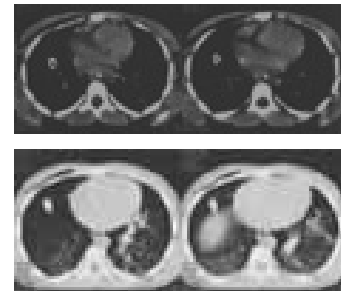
(a-d). Right subcutaneous emphysema (at all scans) and left pneumothorax (at right upper scans) in thoracic CT after settling bilateral thoracic tubes
